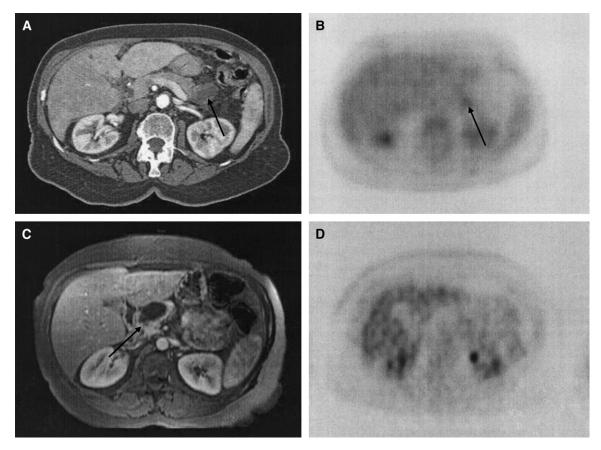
Panel A and B demonstrate a patient with IPMN in situ found in a pancreatic tail lesion with suspicious CT imaging and abnormal uptake on FDG PET imaging. Panel C and D demonstrate a patient with adenocarcinoma in a pancreatic head mass seen on MRI and no areas of corresponding abnormal FDG avidity seen on PET.
